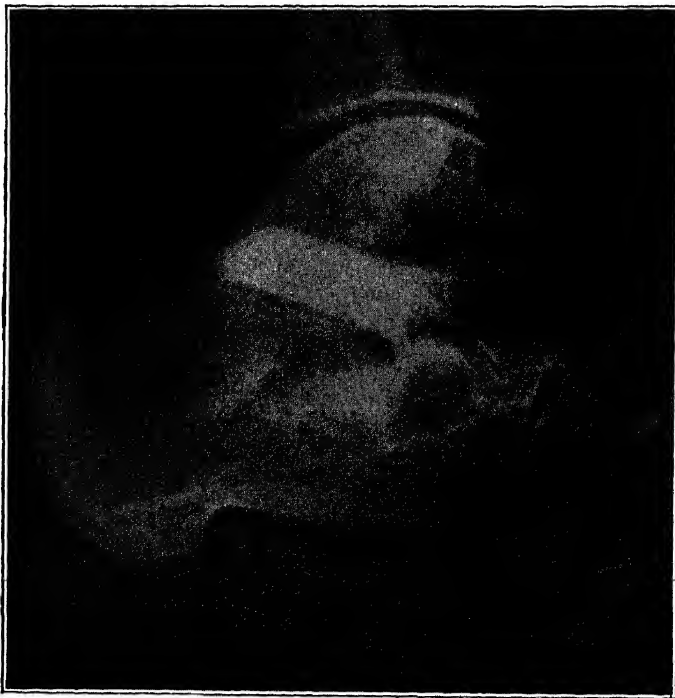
Roentgenogram taken 3 months after operation, showing the grafts uniting to the walls of the mortise. (W. E. Gallie: J. Bone and Joint Surg.)
